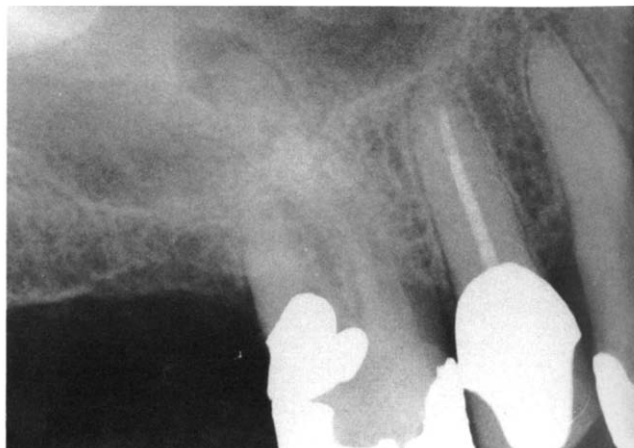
Case 1, preoperative radiograph. Note the radiolucency associated with the palatal root of the maxillary right first molar.
